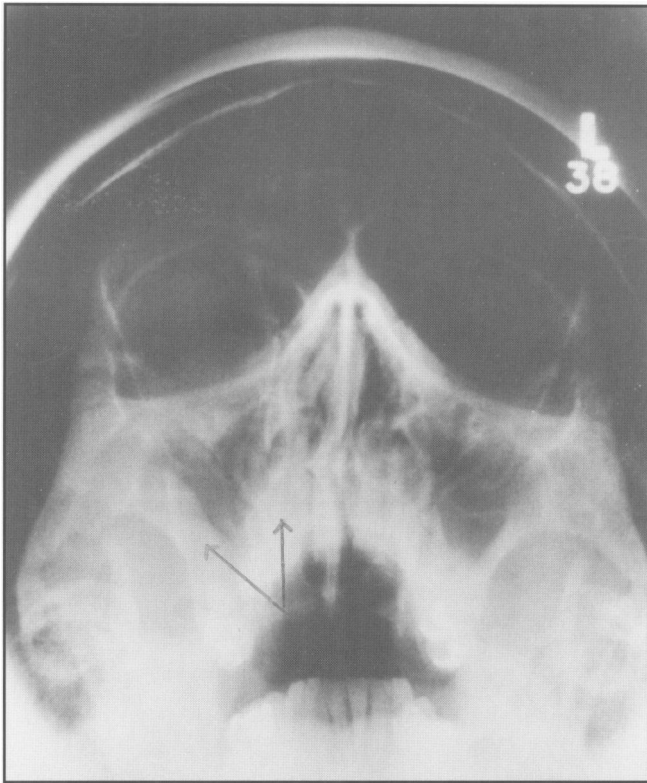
X-ray of maxillae showing right sided mucosal antral thickening.
